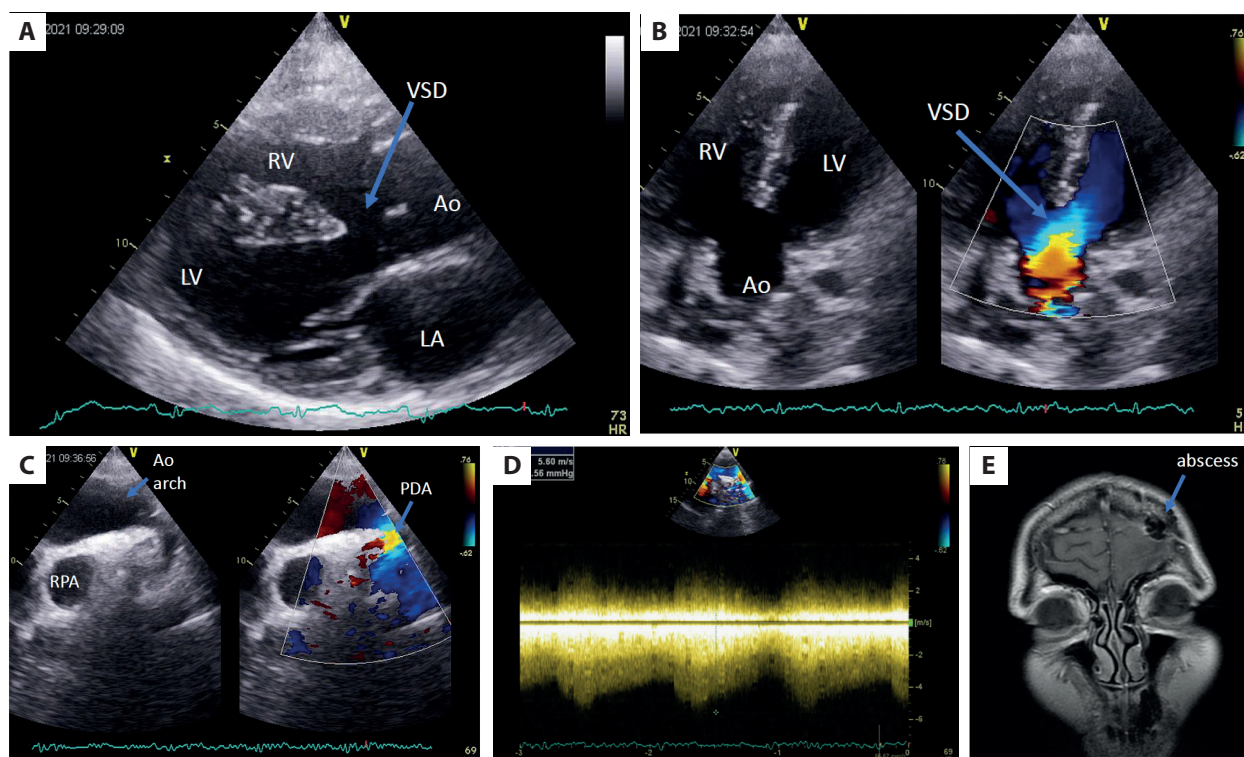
A. Transthoracic echocardiographic examination, parasternal long axis view, nonrestrictive perimembranous ventricular septal defect with bidirectional shunt. B. Transthoracic echocardiographic examination, five-chamber view, nonrestrictive perimembranous ventricular septal defect with bidirectional shunt. C. Transthoracic examination, suprasternal notch view, patent ductus arteriosus. D. Transthoracic examination, suprasternal notch view, continuous Doppler flow through the patent ductus arteriosus. E. Magnetic resonance examination of the brain, coronal plane, site of the abscess indicated with arrow
